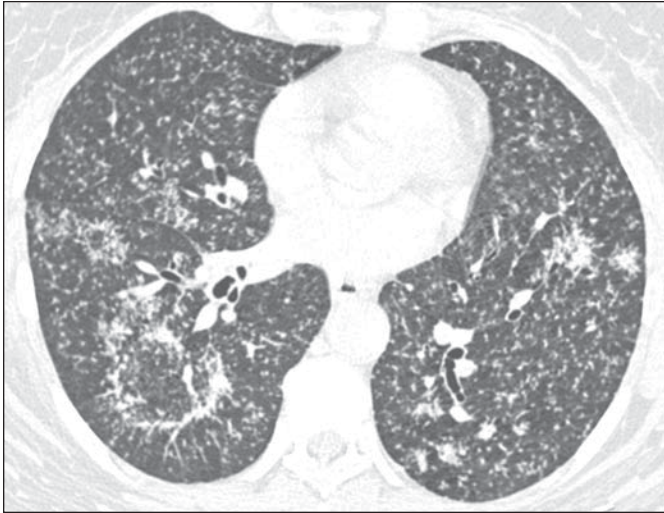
59-year-old woman with pulmonary tuberculosis. High-resolution CT scan of lower pulmonary regions shows bilateral random nodules and two reversed halo signs on right lung. Note that walls of halos are nodular.
